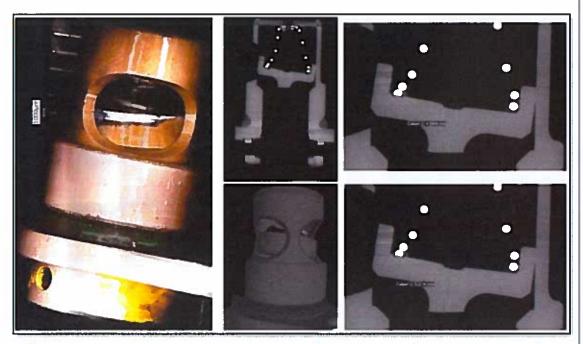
Photograph and CT scan of Yellow MCD showing canted angle of the plunger.
